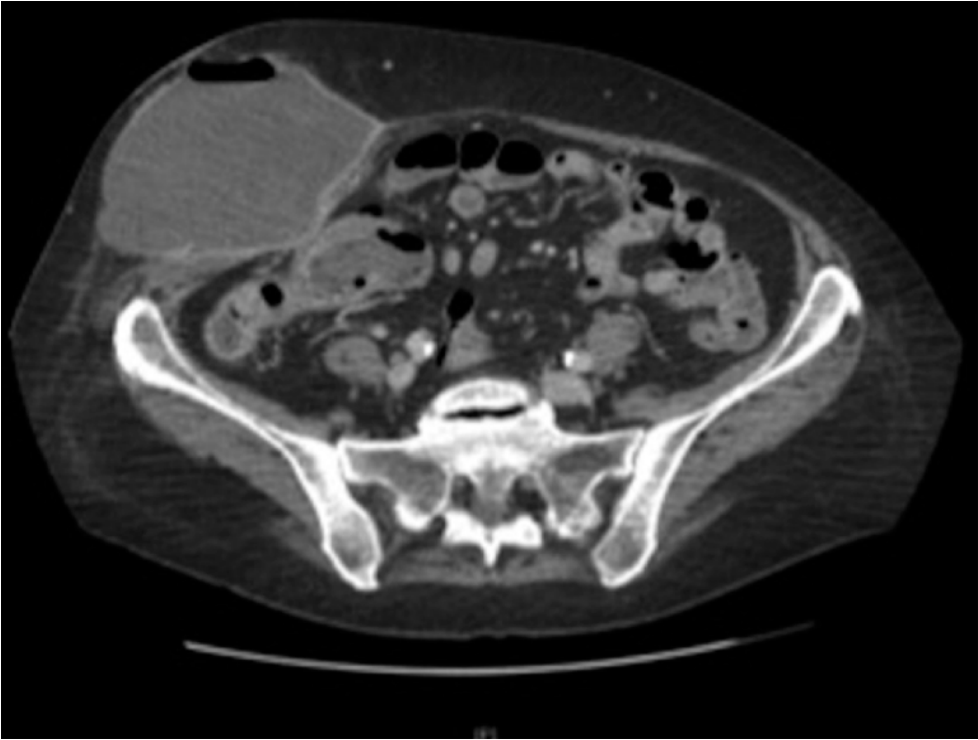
Axial CT of the abdomen showing fistulation and subcutaneous abscess (1)
